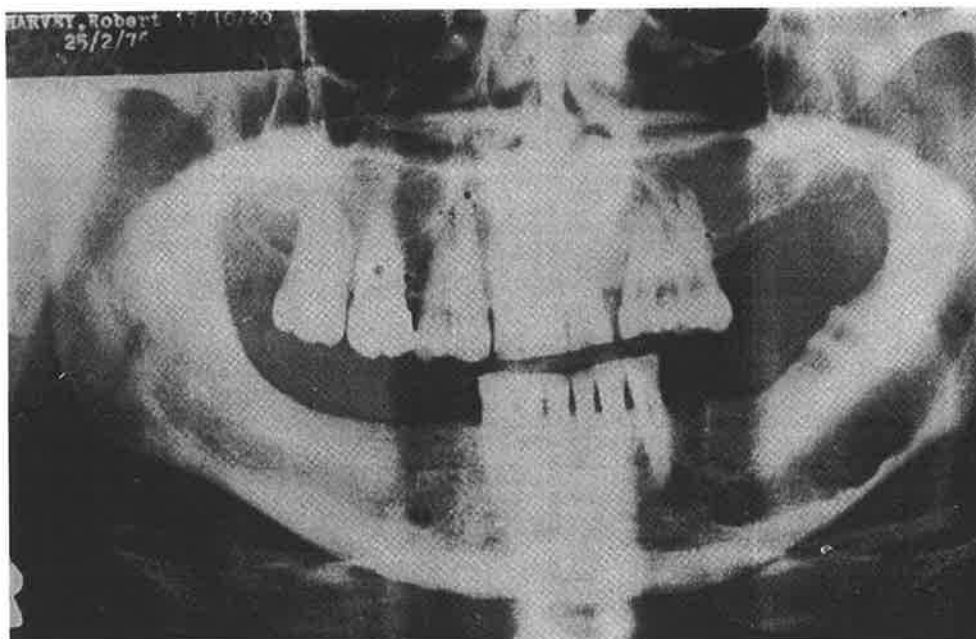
Orthopantomogram showing cylindrical enlargement of inferior dental canal and enlarged left mental foramen.
